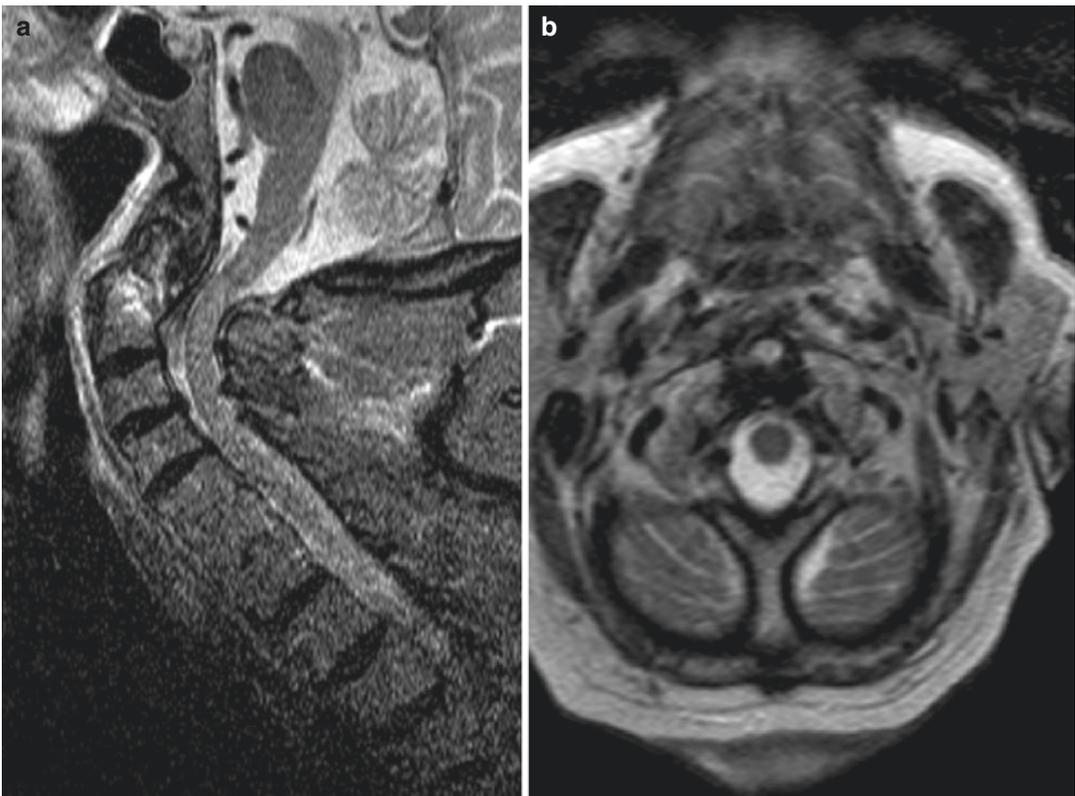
Preoperative MRI. Sagittal STIR MRI (a) showing pathological signal enhancement along the C1/C2 complex; the sagittal and additionally axial images (b) are indicative for the disruption of the transverse ligament of the atlas
